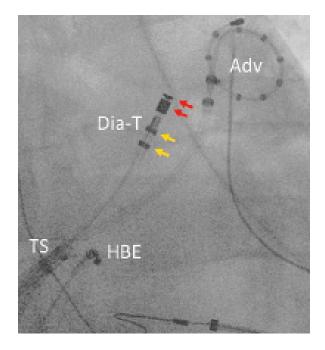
X-ray from the first clinical procedure using DiamondTemp ablation system. Adv – Advisor circular multipolar mapping catheter in the left superior pulmonary vein. Dia-T – the DiamondTemp catheter in the left atrial roof proximal to the left superior pulmonary vein ostium. Red arrows – two distal RF electrodes, yellow arrows – proximal diagnostic ring electrodes, HBE – the quadripolar catheter in His bundle position, TS – transseptal sheath.
